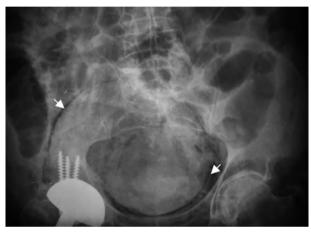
Radiography of the abdomen in which distension of loops of the small intestine and colon may be seen together with the urinary bladder delimited by an aerial line (arrows).
